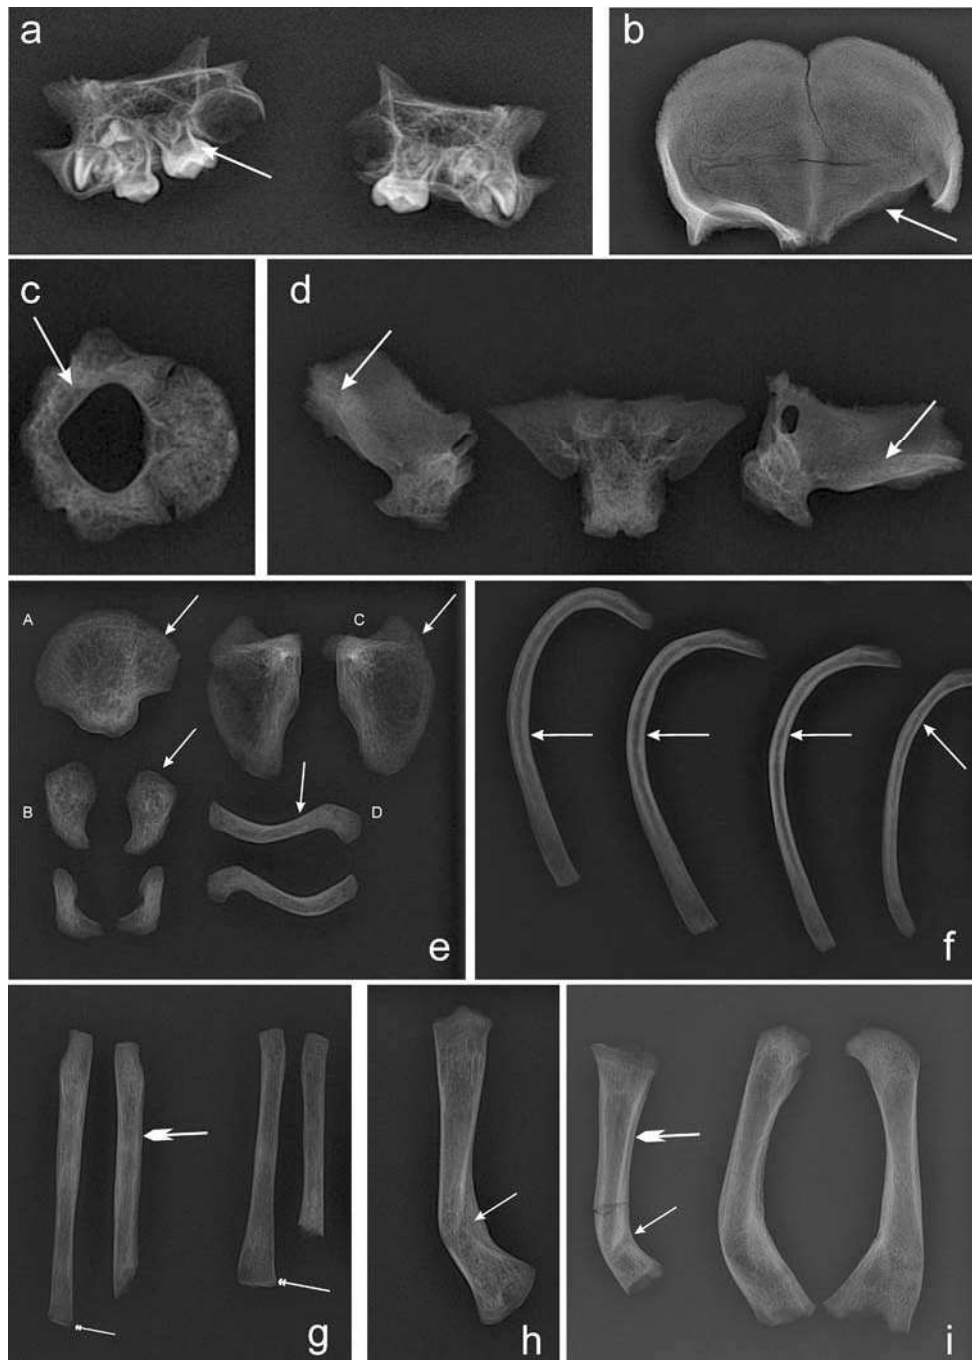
Radiographs of the right and left maxilla; the arrow points to the enlarged pulp chamber of the second deciduous molar (a); The frontal bone, with the arrow pointing to the thickened area (b); coarse trabecular pattern on the lumbar vertebra (c, arrow); increased density of the wings of the sphenoid bone (d, arrows); coarse trabecular structure, but no increase in the cortical thickness (arrows) of the right ilium (A), the right and left ischia and pubic bones (B), the scapulae (C) and the clavicles (D) (all 6e); thickened cortices of the ribs (f, arrows); radii and ulnae (g), with double arrows pointing to well-defined metaphyseal ends, and the long arrow pointing to periosteal new bone; the right humerus (h), and the left tibia and both femora (i); arrows show the healed fractures on the right humerus and the left tibia; the long arrow points to periosteal new bone on the tibial shaft.
